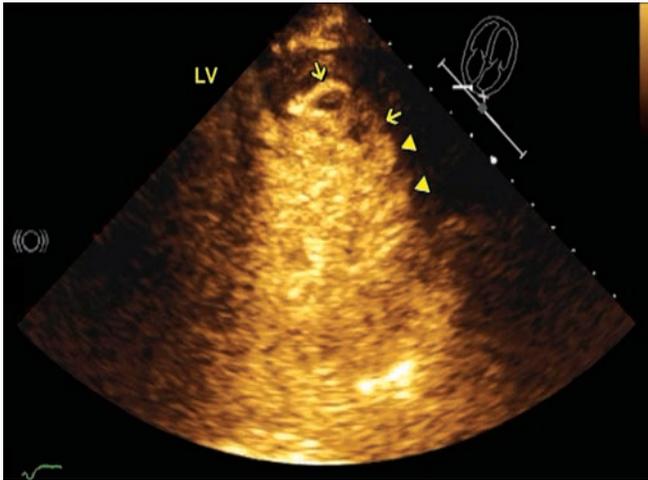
Focused 4-chamber view of contrast echocardiogram showed unstable thrombus (arrows) in trabecular recesses (arrowheads).
